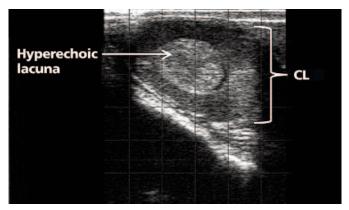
Ultrasound image of a corpus luteum (CL) with a haemorrhagic lacuna. CL appears as a grey, circular structure (brackets) and hyperechoic lacuna as a light grey, circular structure in the middle (arrow). Image obtained using BCF Easi-Scan.
